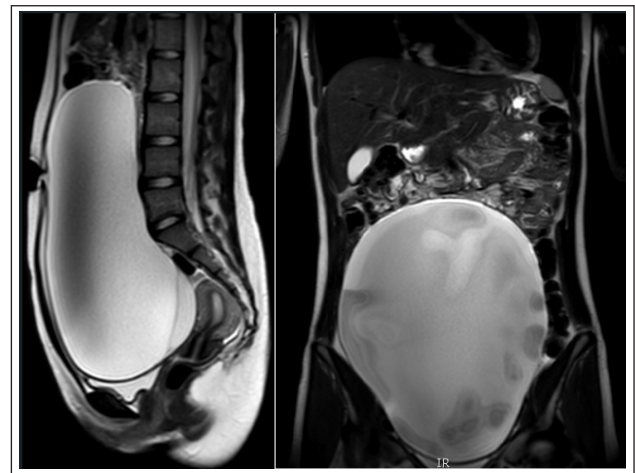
Abdominal MRI scan - coronal and sagittal sections
